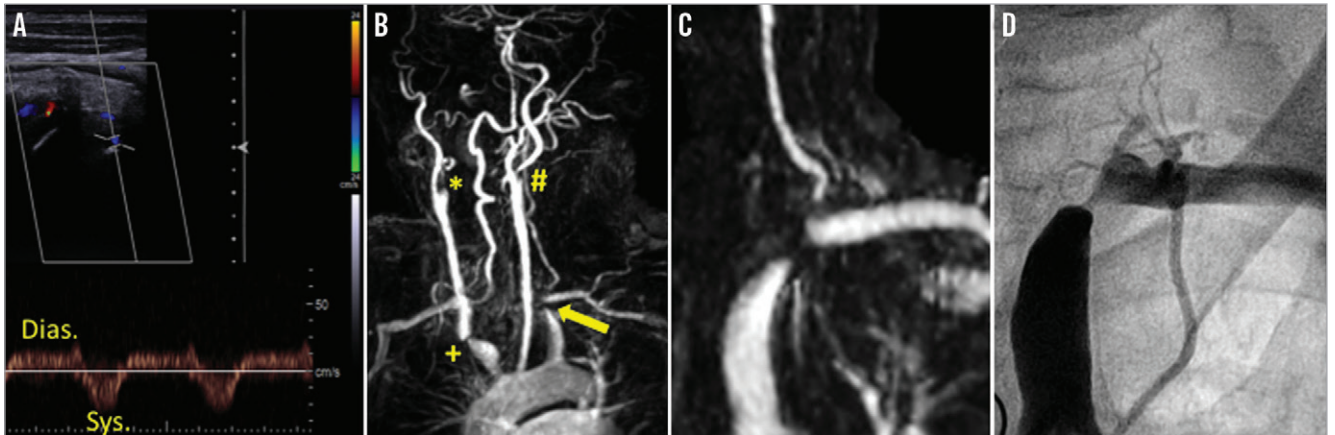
Subclavian steal syndrome caused by advanced supra-aortic disease. *A) Colour-coded Doppler ultrasound imaging of subclavian steal syndrome demonstrating an alternating flow within the extracranial left vertebral artery (VA) under resting conditions with antegrade flow in the diastolic (Dias.) and retrograde flow in the systolic (Sys.) phase due to severe stenosis of the proximal left subclavian artery (SA). B) MR angiography of the supra-aortic arteries revealing filiform stenosis of the left SA (arrow) as well as the concomitant lesions including occlusion of the right (*) and stenosis of the left internal carotid artery (#) and of the innominate artery (+). C) Magnification of the MRA demonstrates the close relation of the high grade stenosis of the left SA and the nearby stenosis of the VA. D) Conventional angiography clearly demonstrates the SA stenosis and the retrograde perfused nearby VA as well as the antegrade perfused LIMA origin.*
